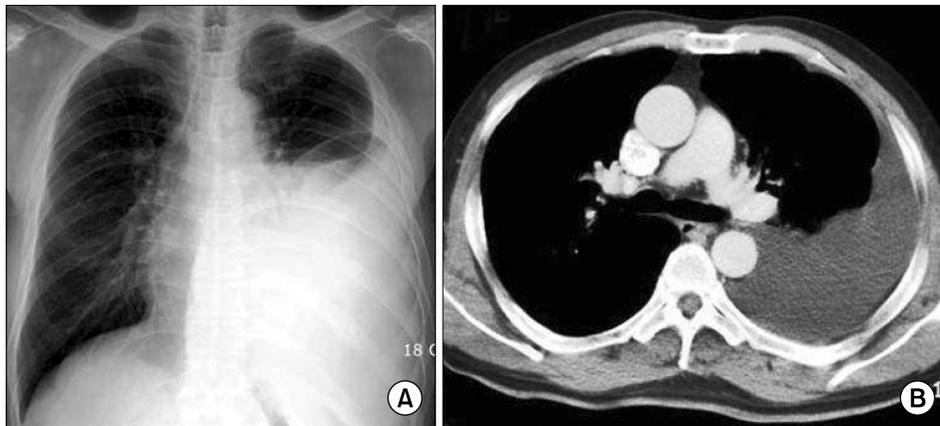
Chest radiograph on the day of admission showed a left pleural effusion (A). Contrast-enhanced chest computed tomography showed a left-sided, unilateral pleural effusion, and collapse of the left lung with no pathologic endobronchial mass or lymphadenopathy (B).
